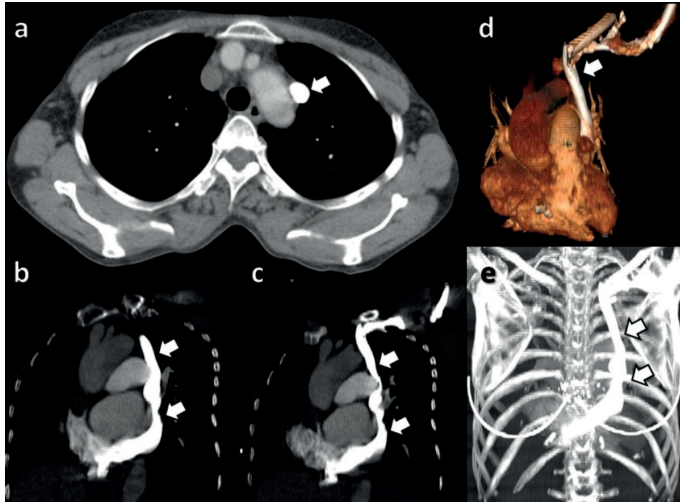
After left arm IV contrast administration, axial contrast enhanced thorax CT image (a), coronal MPR images (b, c), 3D reformat image (d) and MIP image (e) shows the persistent left vena cava superior vein (white arrows).
